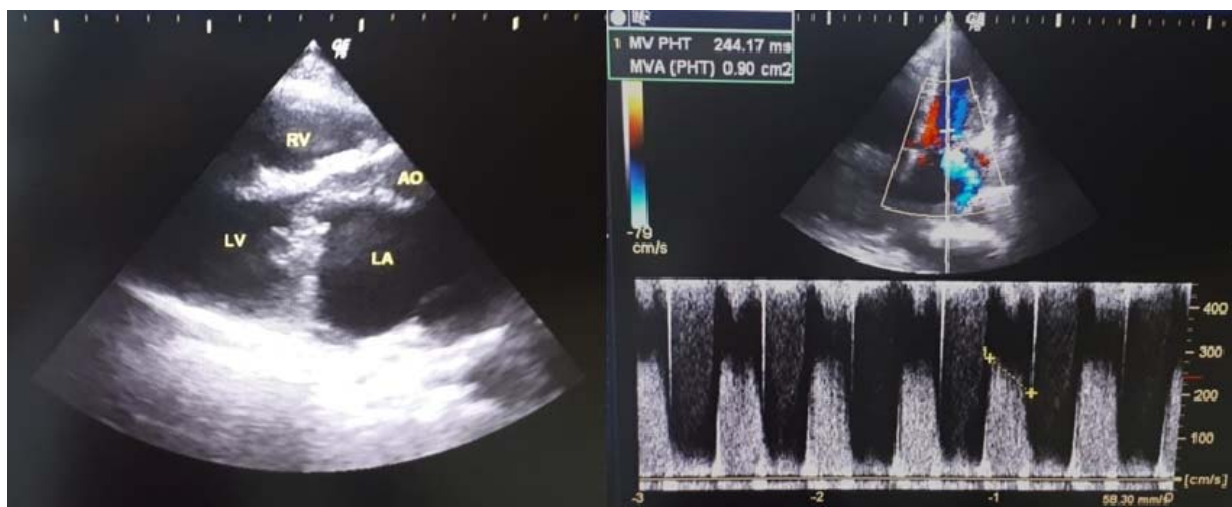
Echocardiography showed mitral stenosis with dilated left atrium
